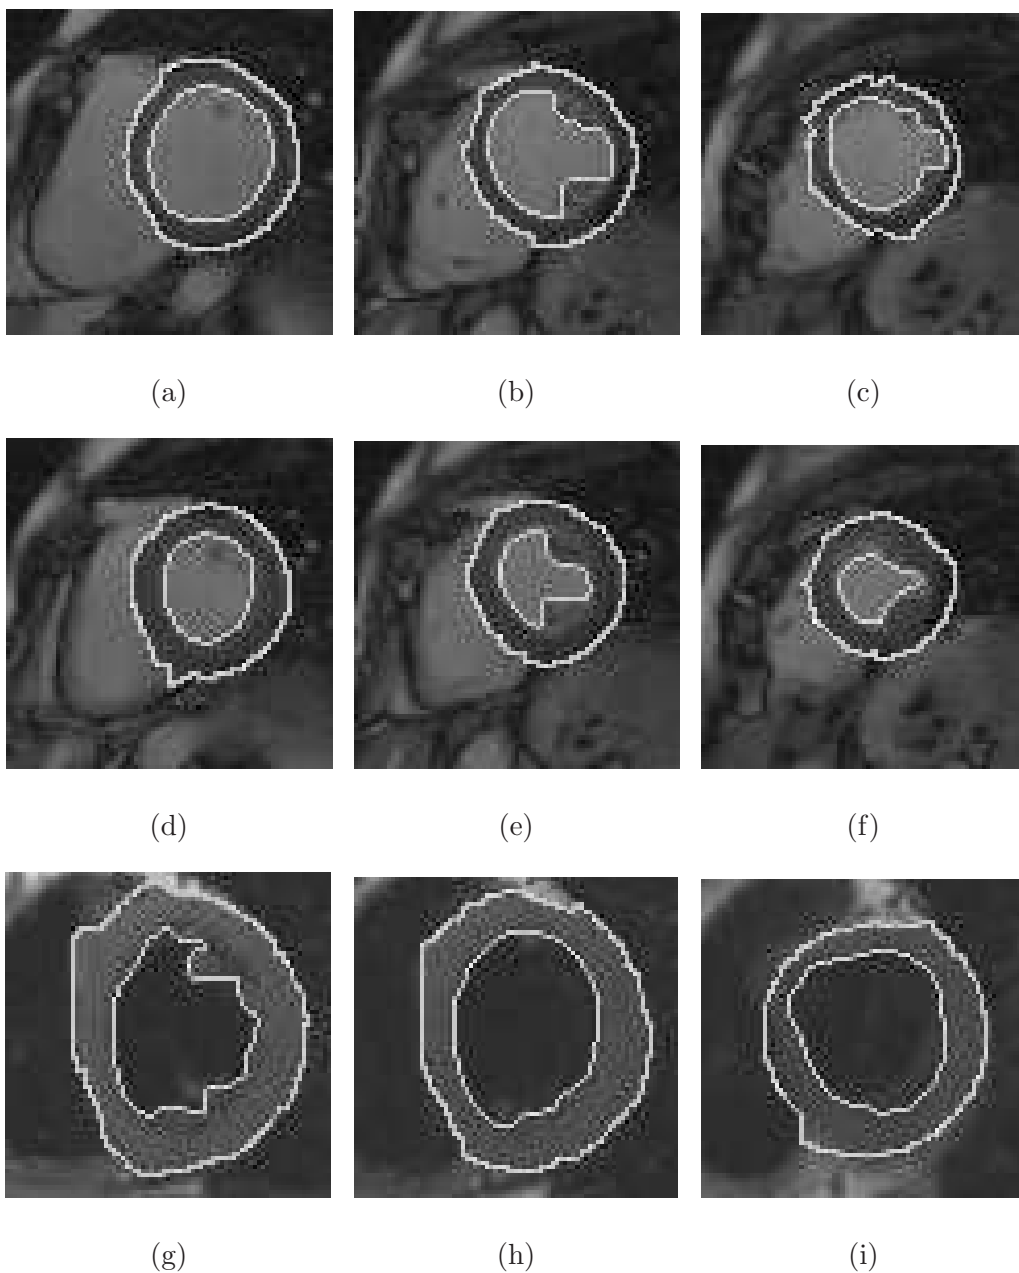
The left ventricle contours obtained using our automatic segmentation method in short axis cardiac MR images. Figures (a)-(f) show images taken at both the end-diastolic phase and end-systolic phase of a gradient-echo sequence. Figures (g)-(i) show images from a spin-echo study.
